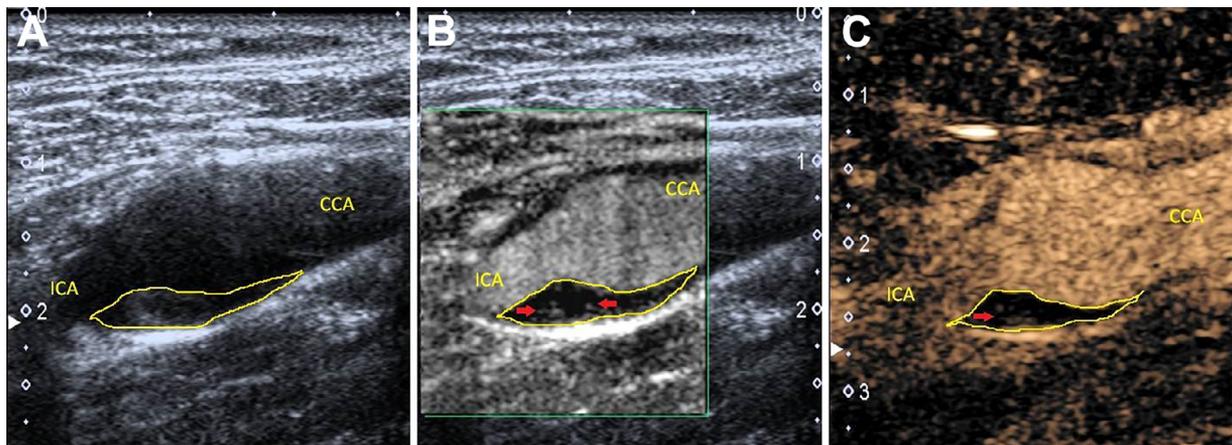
Grayscale ultrasound, SMI, and CEUS images in one 67-year-old male patient at T0. (A) Grayscale ultrasound sagittal image. (B) SMI sagittal image. (C) CEUS sagittal image. Abbreviations: ICA, internal carotid artery; CCA, common carotid artery; CEUS, contrast-enhanced ultrasonography; SMI, superb microvascular imaging; T0, baseline. (Color version of figure is available online.)
